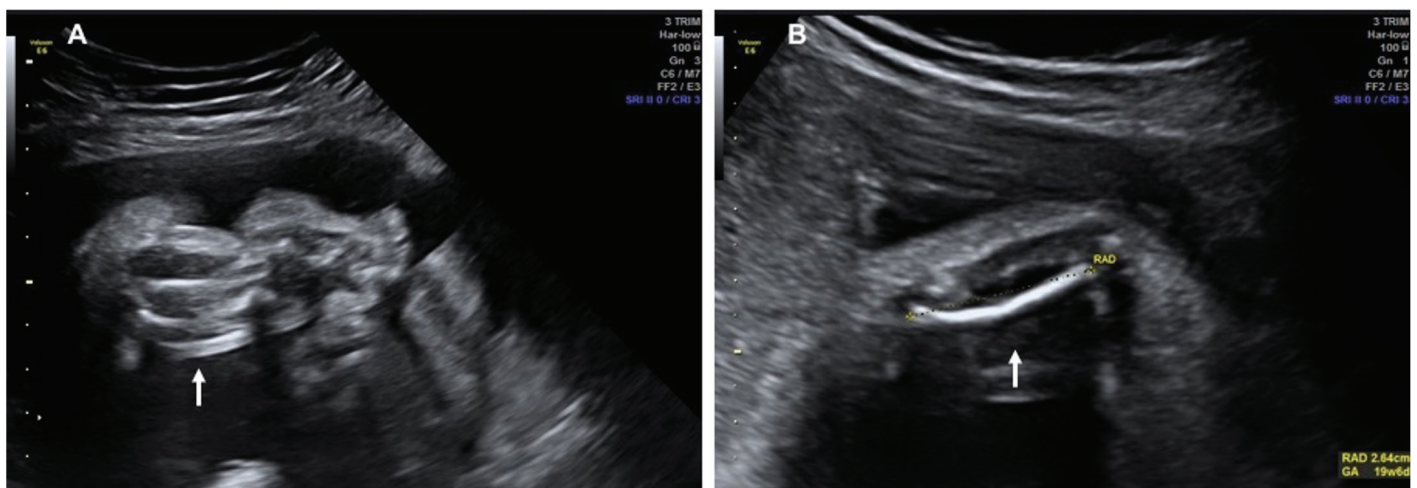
Two-dimensional (2D) ultrasound images of the fetus at 27 weeks of gestation showing lower and upper limbs. (A) Short lower limb (arrow). (B) Short upper limb (arrow)
